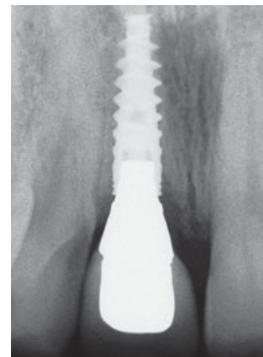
Periapical radiograph of the definitive restoration at 12 months.
